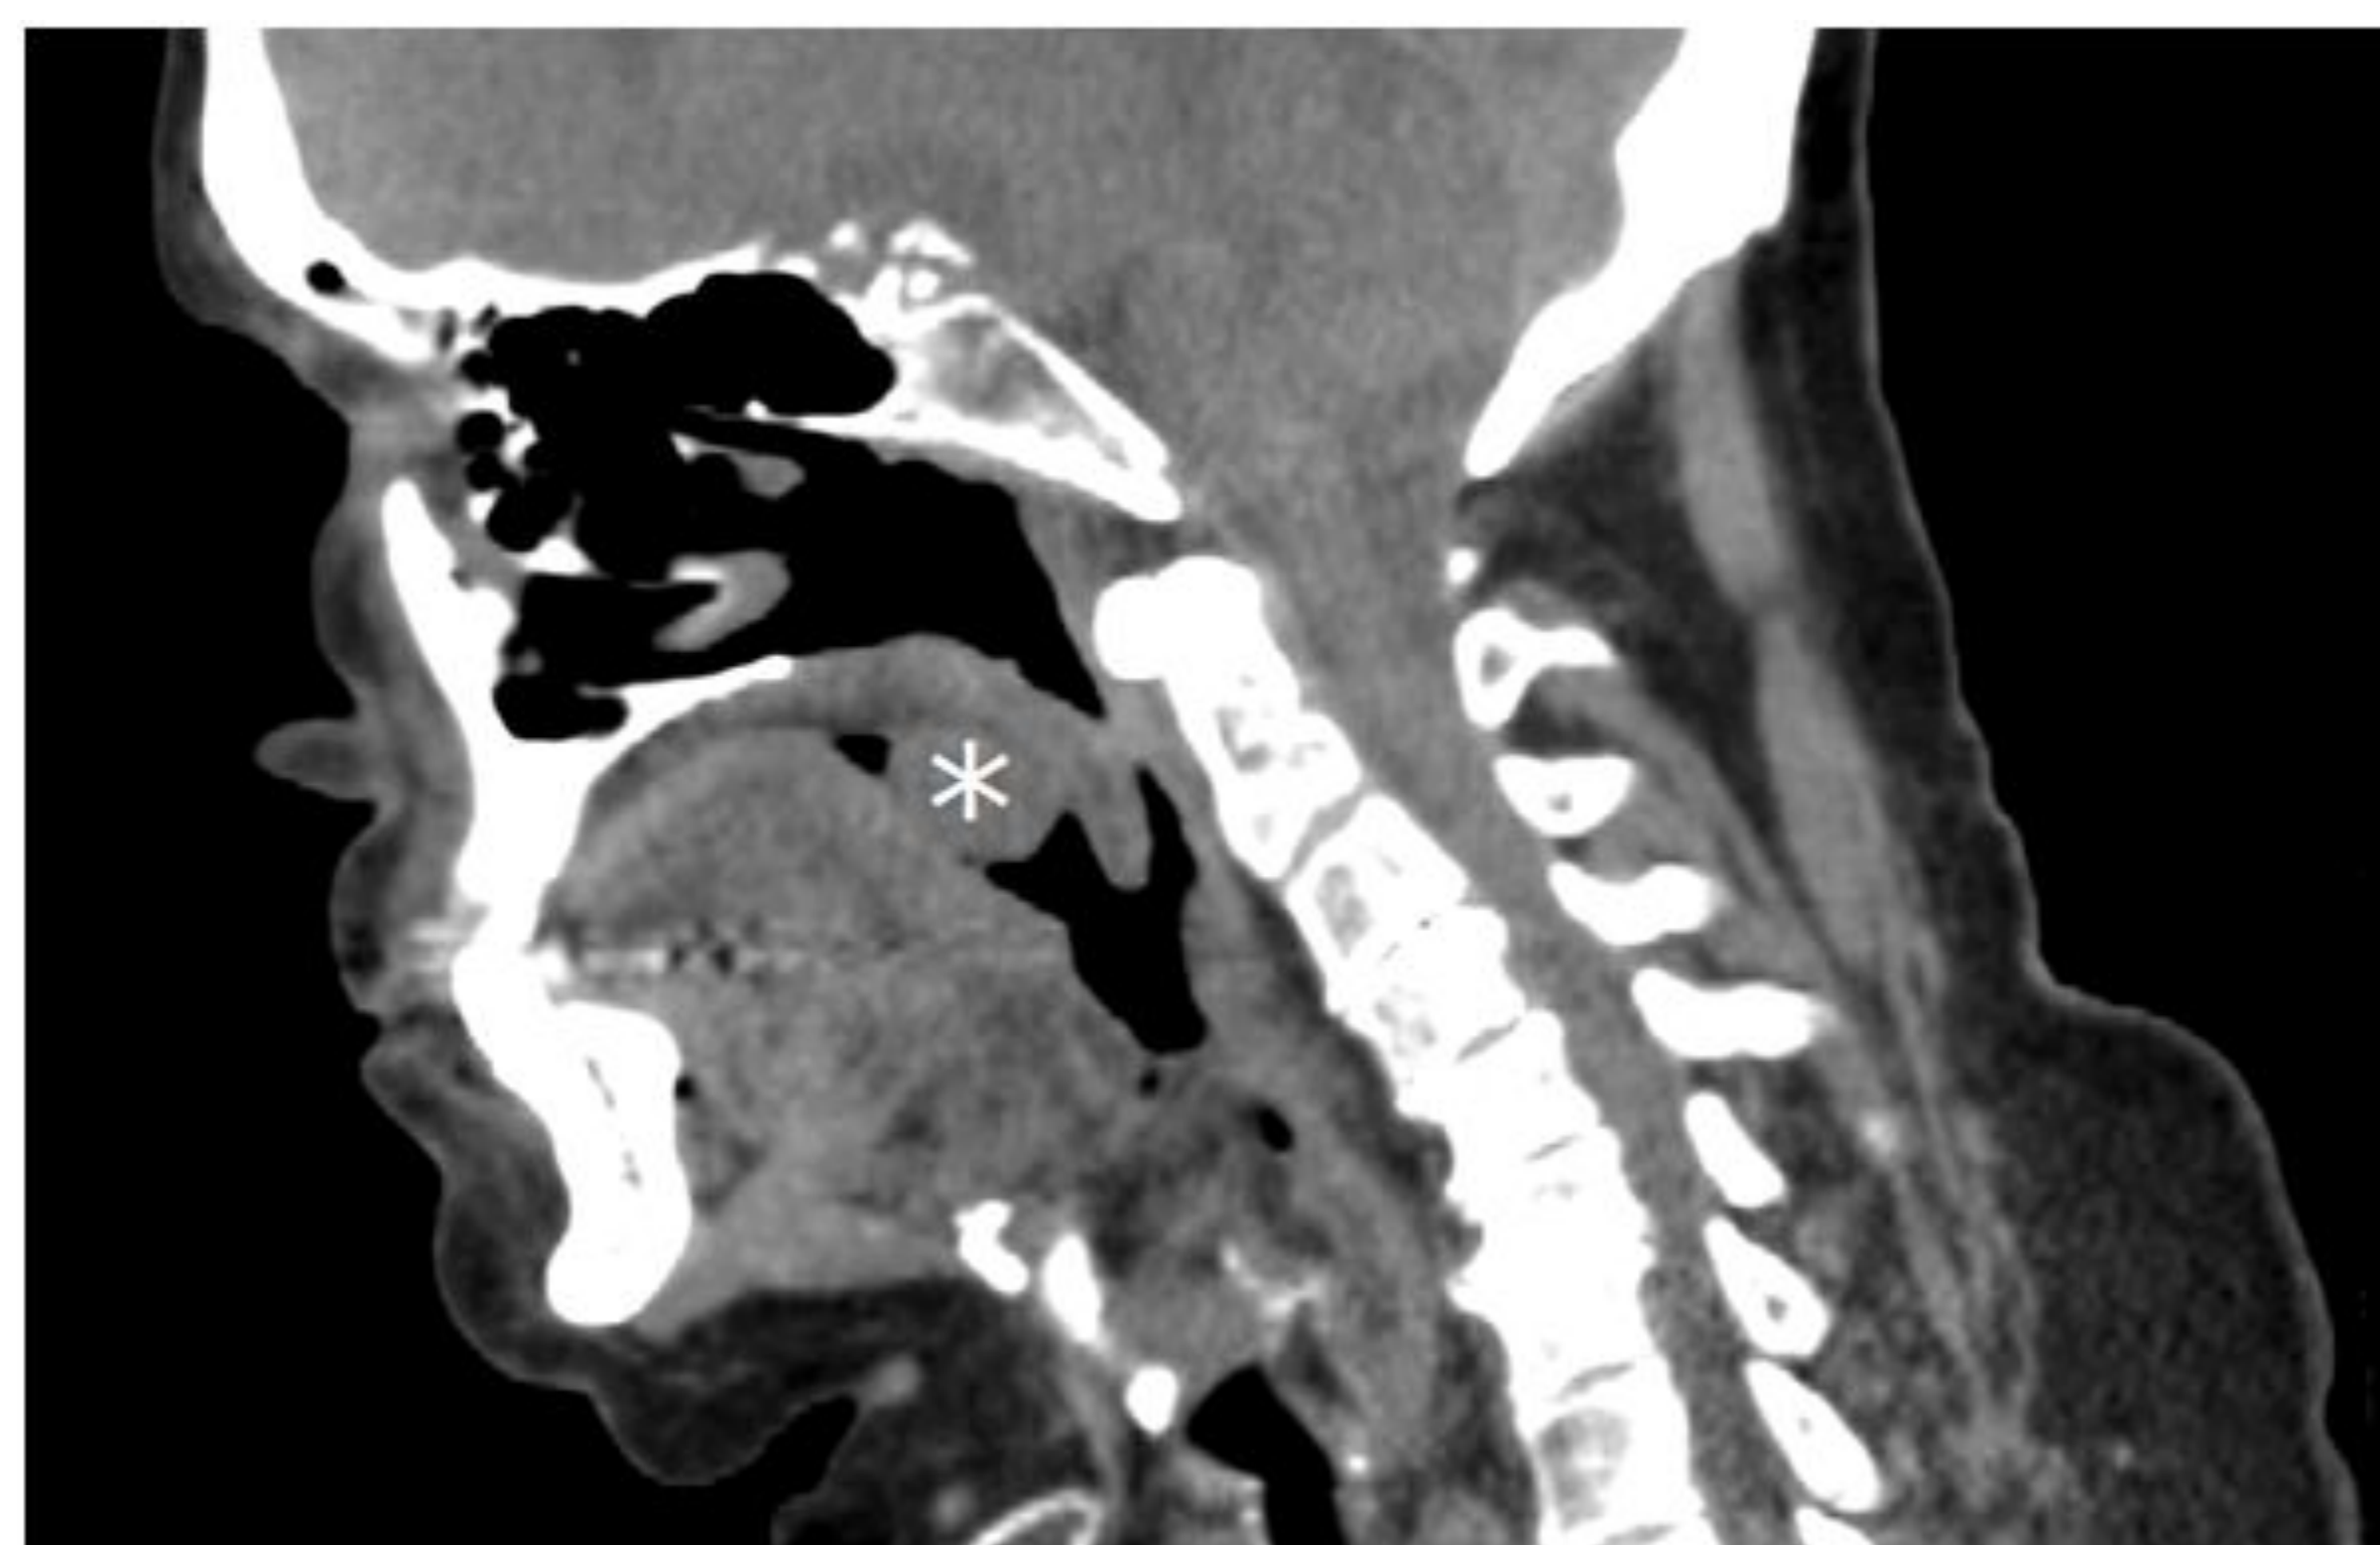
Unenhanced CT image of soft palate mass(\*) in sagittal view measuring 22 x 16 x 20mm (TR x AP x CC) and separate from the base of the tongue
